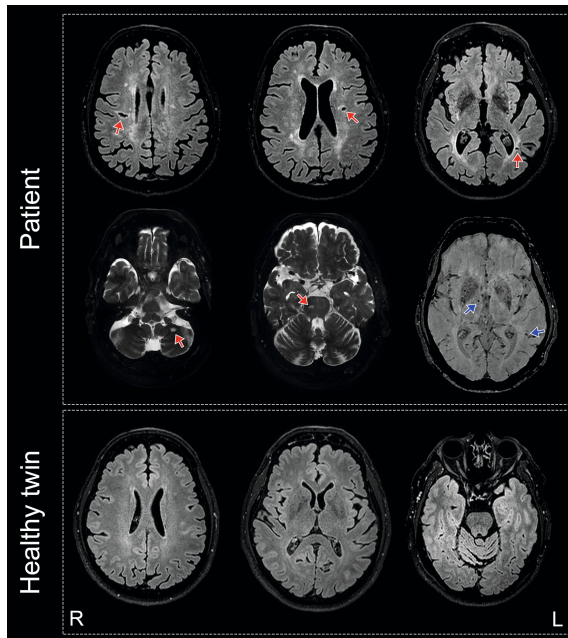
Brain MRI for the patient and healthy twin (age 62 years). Representative axial slices are shown. Fluid-attenuated inversion recovery sequences are shown for the patient (top row) and healthy twin (bottom row), and T2-weighted (middle row, left and center image) and susceptibility-weighted sequences (middle row, right image) are shown for the patient. Red arrows indicate lacunar infarcts and blue arrows indicate cerebral microbleeds. R = right, L = left.
